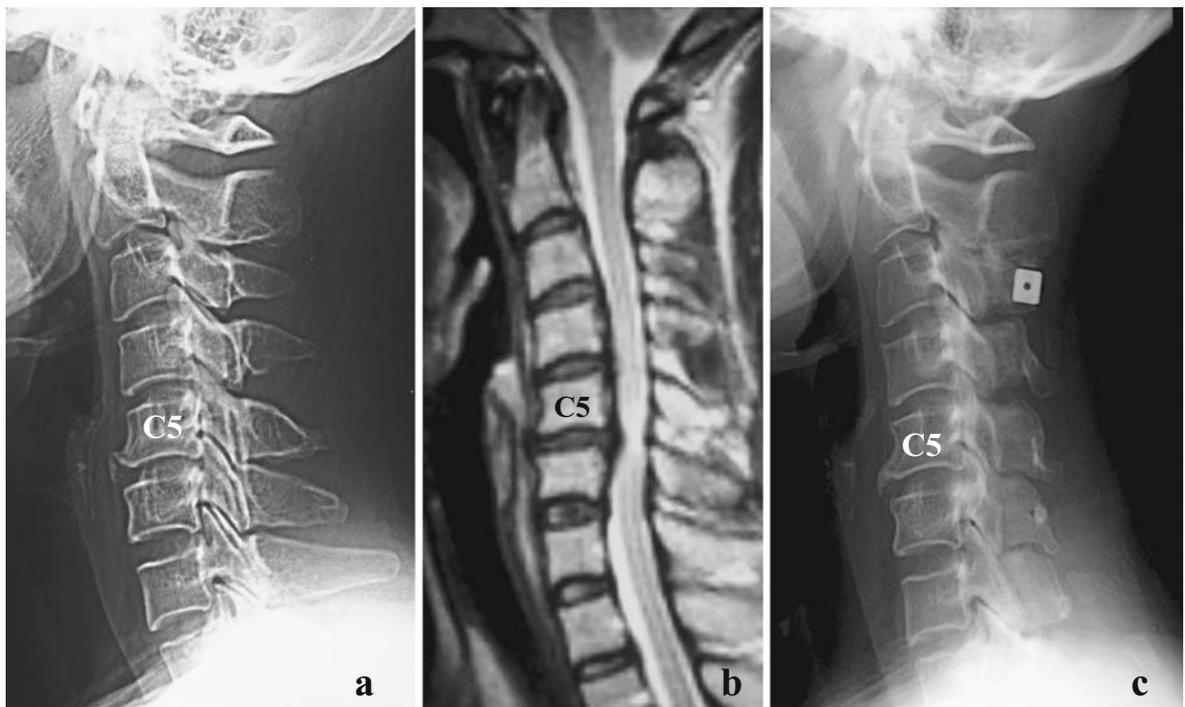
Postoperative progression of cervical OPLL in a 42-year-old woman. a Radiograph shows a small area of segmental-type OPLL at C4 and at C5 before the operation. b T2-weighted sagittal MRI shows spinal cord compression
